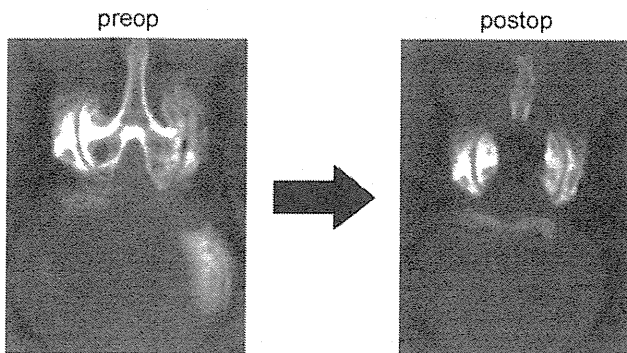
Preoperative (*left*) and postoperative (*right*) CT scans. *Left*: Preoperative CT shows severe spinal stenosis with narrow and steep facet joints. *Right*: Postoperative CT shows a sufficient trumpeted decompression of the spinal canal with preservation of the facet joints.
